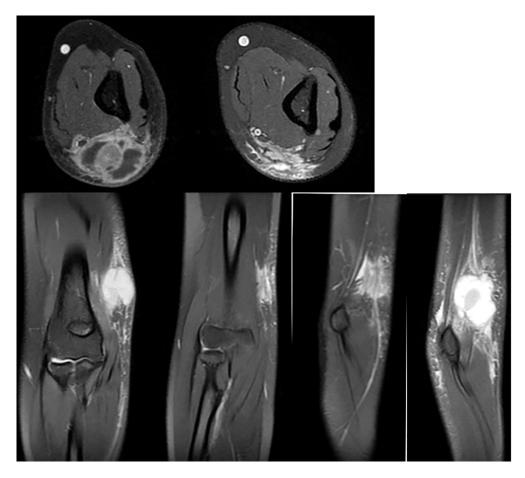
MRI with and without contrast of the elbow, axial, coronal and sagittal views of the T1-fat suppressed post contrast sequence, demonstrating the mass in further detail with areas of necrosis and enhancing central nodule. The mass is abutting the ulnar nerve.
